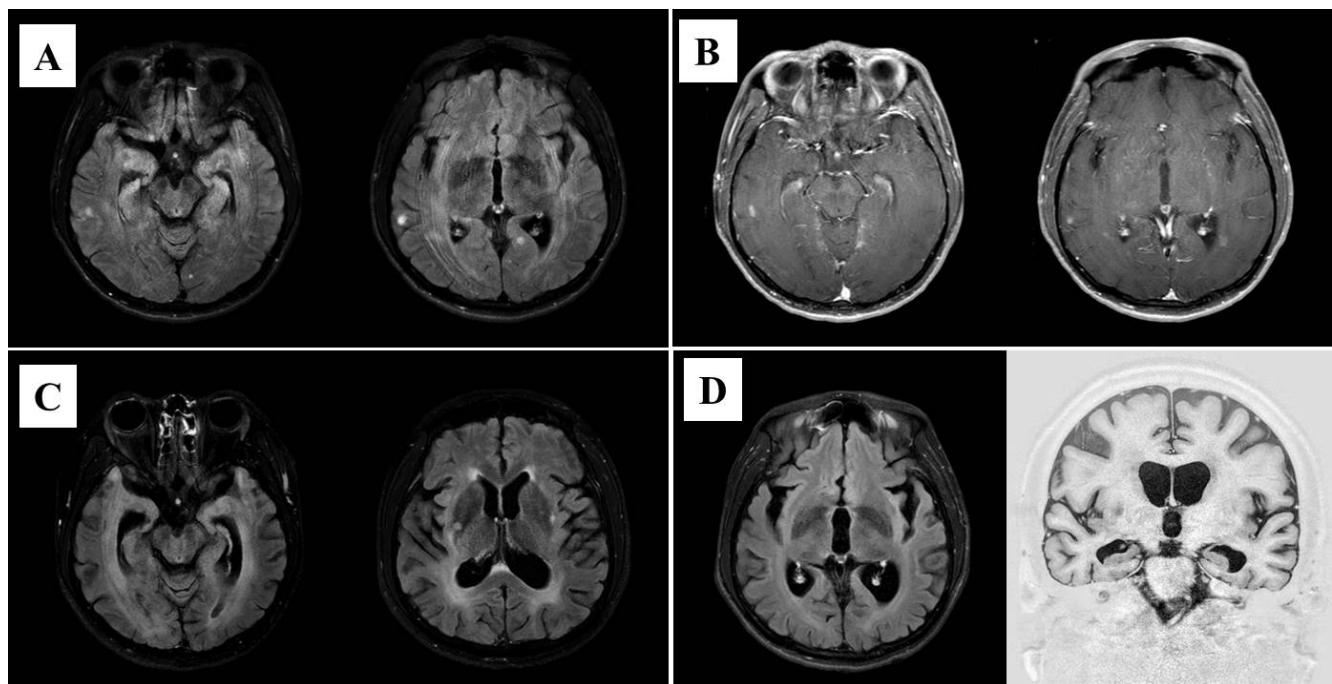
Brain magnetic resonance imaging (MRI), using fluid-attenuated inversion recovery (A) and gadolinium-enhanced T1-weighting (B), revealed multiple high-signal lesions with enhancement in the bilateral cerebral cortex, subcortex, and deep white matter. After 6 months later, a brain MRI showed newly developed, small, T2 high-signal intensities in the right posterior basal ganglia, left external capsule and both temporal lobe with advanced brain atrophy (C). And a recent followed-up brain MRI showed aggravated brain atrophy with third and lateral ventricular dilatation (D).
